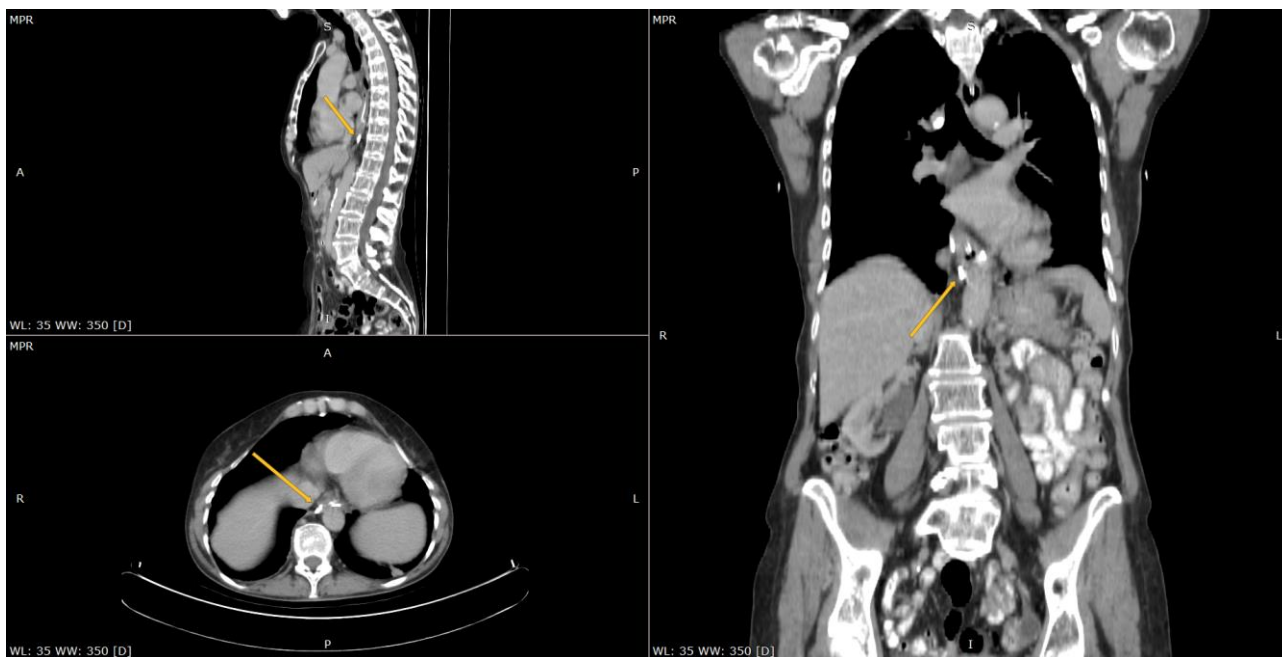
BioXmark® (yellow arrow) in the esophagus on 62 days follow-up CT.
